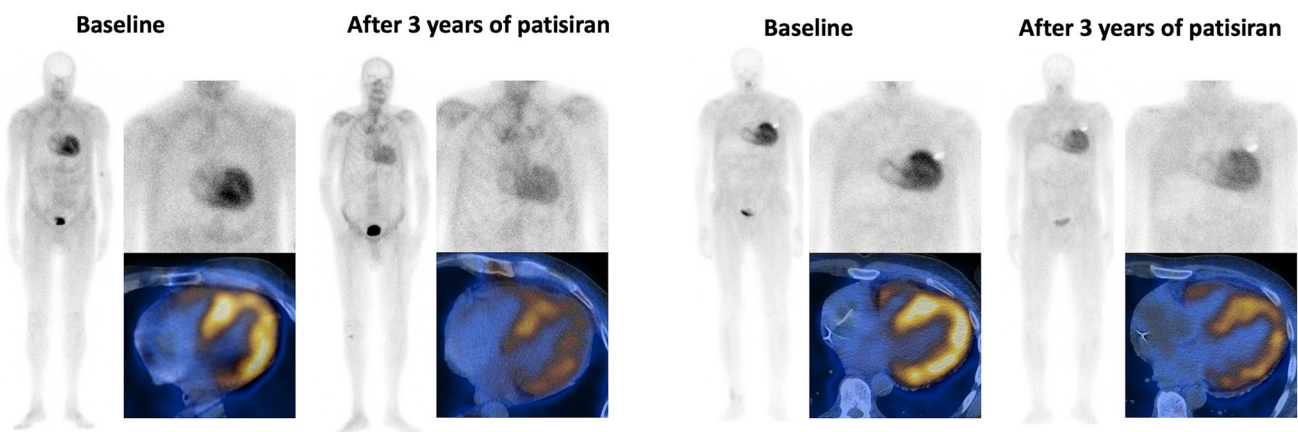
Bone scintigraphy planar and single-photon emission computed tomography (SPECT) images demonstrating reduced cardiac radiotracer uptake following 3 years of patisiran therapy
